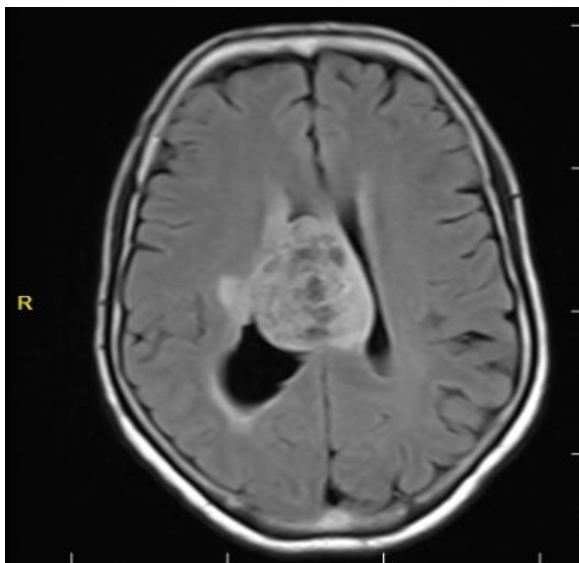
Brain MRI Axial Flair view, showing hyperintense heterogeneous intraventricular lesion with mild edema
